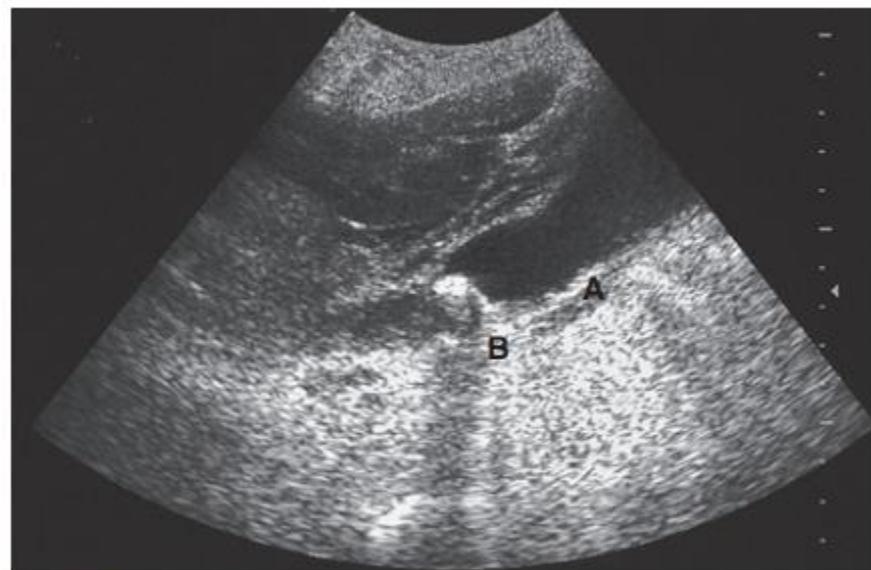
Ultrasound scan of the gallbladder. *A*, Thick-walled gallbladder containing gallstones. *B*, Posterior acoustic shadowing.
